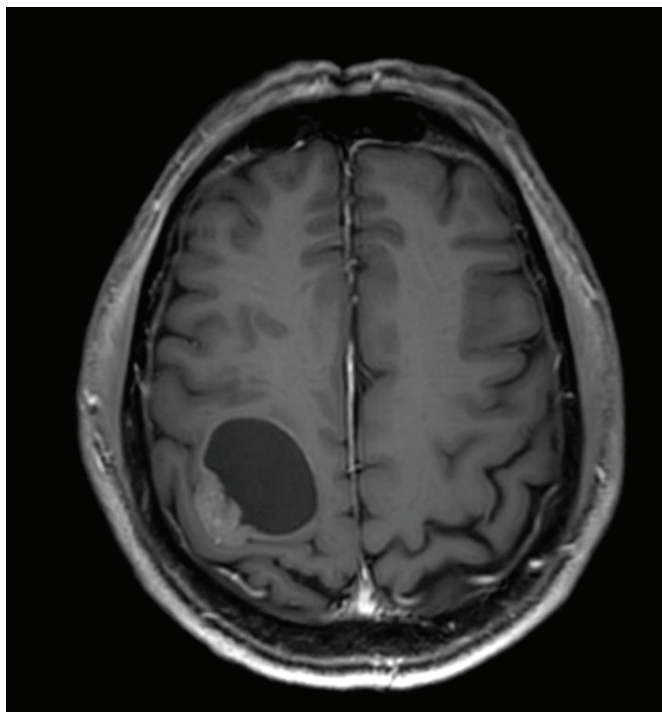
Magnetic resonance imaging of the brain in case 2. Axial T1-weighted contrast-enhanced images demonstrate cystic metastasis of lung cancer in the right frontoparietal lobe.
